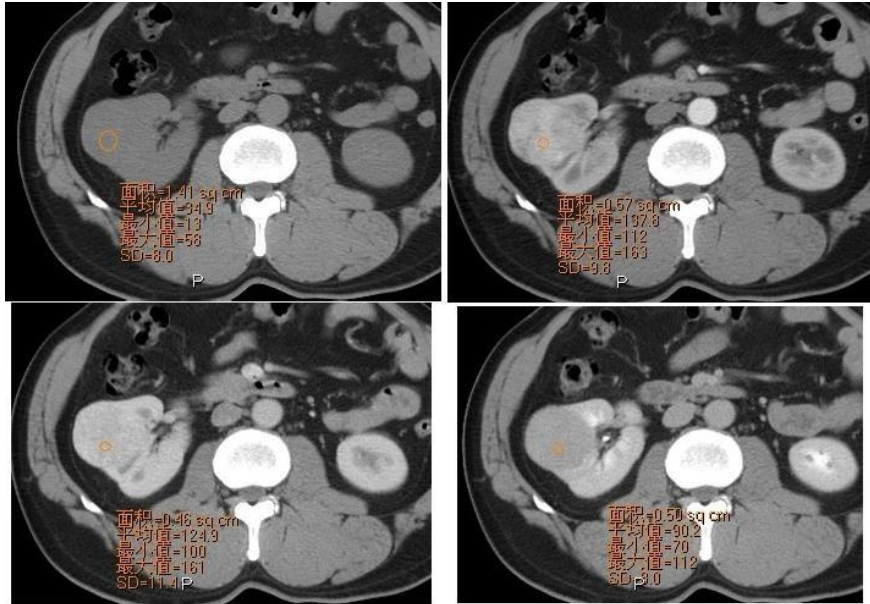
Male, 72years, right chromophobe;(A). unenhanced CT shows round, lobular homogeneous mass in the upper pole of the right kidney with CT value of 34HU;(B). In corticomedullary phase mass shows obviously heterogeneous mass with CT value of 137HU;(C).the CT value of the same location shows 124HU in parenchymal phase;(D).In the excretory phase the CTvalue shows 90HU.
